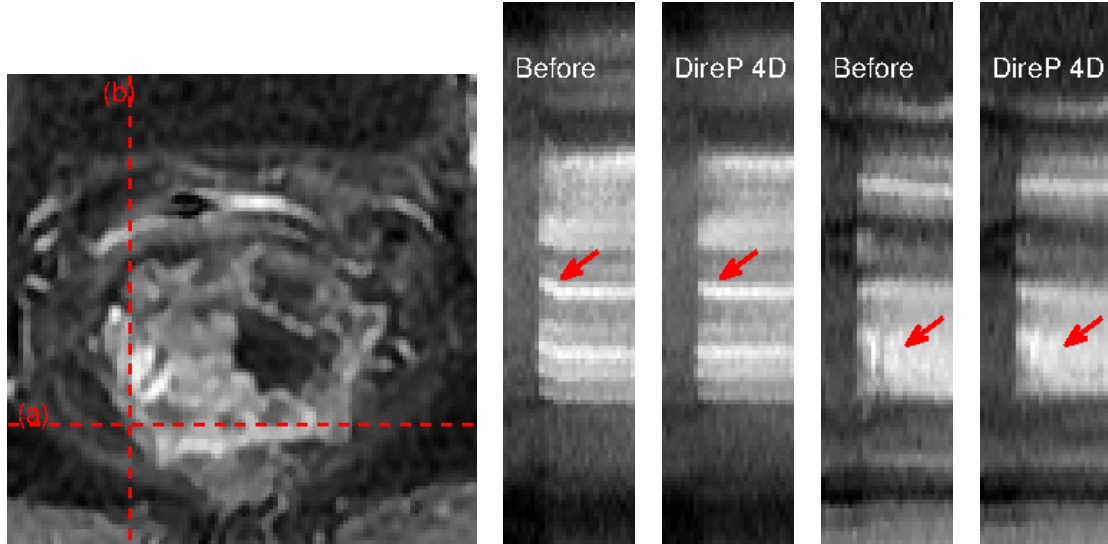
Effects of registration on an image sequence of the Sonatina dataset are shown using time-cuts. The leftmost image represents a slice through the DCE-MRI volume of interest. The middle two images represent time-cuts for line (a) in the DCE-MRI image. The rightmost two images represent time-cuts for line (b) in the DCE-MRI image. Red arrows indicate regions in the tumour where the improved alignment after registration can be observed.
